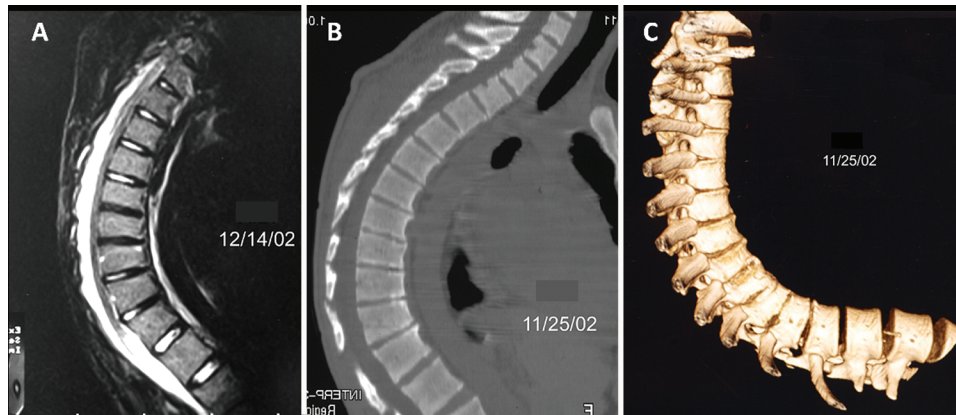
Case 1. Preoperative T2-weighted sagittal MR image (A), sagittally reconstructed CT scan (B), and 3D CT reconstruction (C). Note the gradual, sweeping kyphosis, ideally suited to a series of SPOs.
